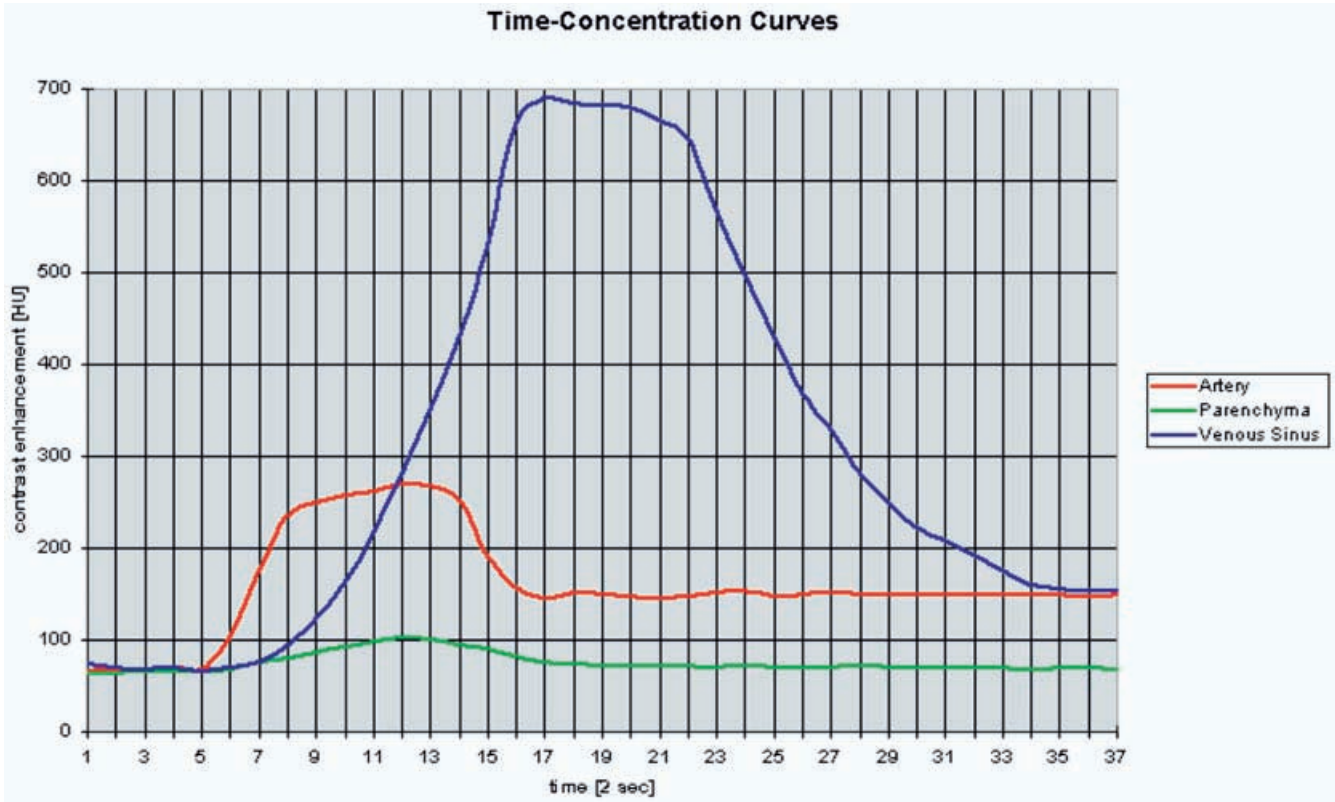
Time–concentration curves obtained from the patient’s perfusion CT series in an arterial pixel, in a parenchymal pixel, and in a pixel at the center of the superior sagittal venous sinus, respectively. Contrast enhancement in Hounsfield units is considered with respect to time expressed in steps of 2 s. Two elements are noteworthy: Firstly, contrast enhancement is more marked in the venous pixel than in the arterial and parenchymal pixels, due to the different sizes of the corresponding vessels, with, as a result, a more or less important partial-volume averaging effect. Secondly, the parenchymal time–concentration curve compared with the arterial curve, and the venous time–concentration curve compared with the parenchymal curve, show more and more flattened profiles as well as more and more delayed peak with regard to time. This relates to the iodinated contrast material first traveling in arteries, then in parenchymatous capillaries and finally in veins
